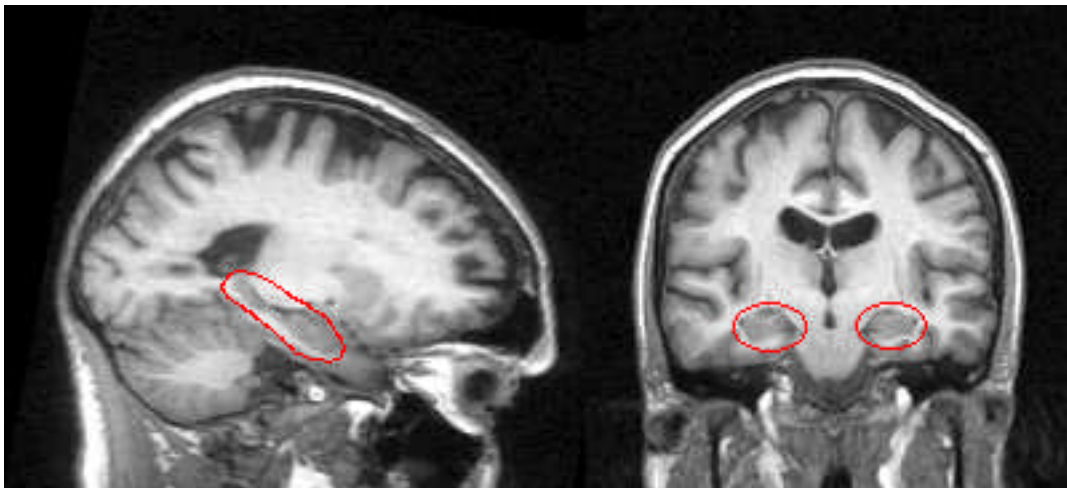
Sagittal and coronal MRI views of the hippocampus. The hippocampal region is circled in red
